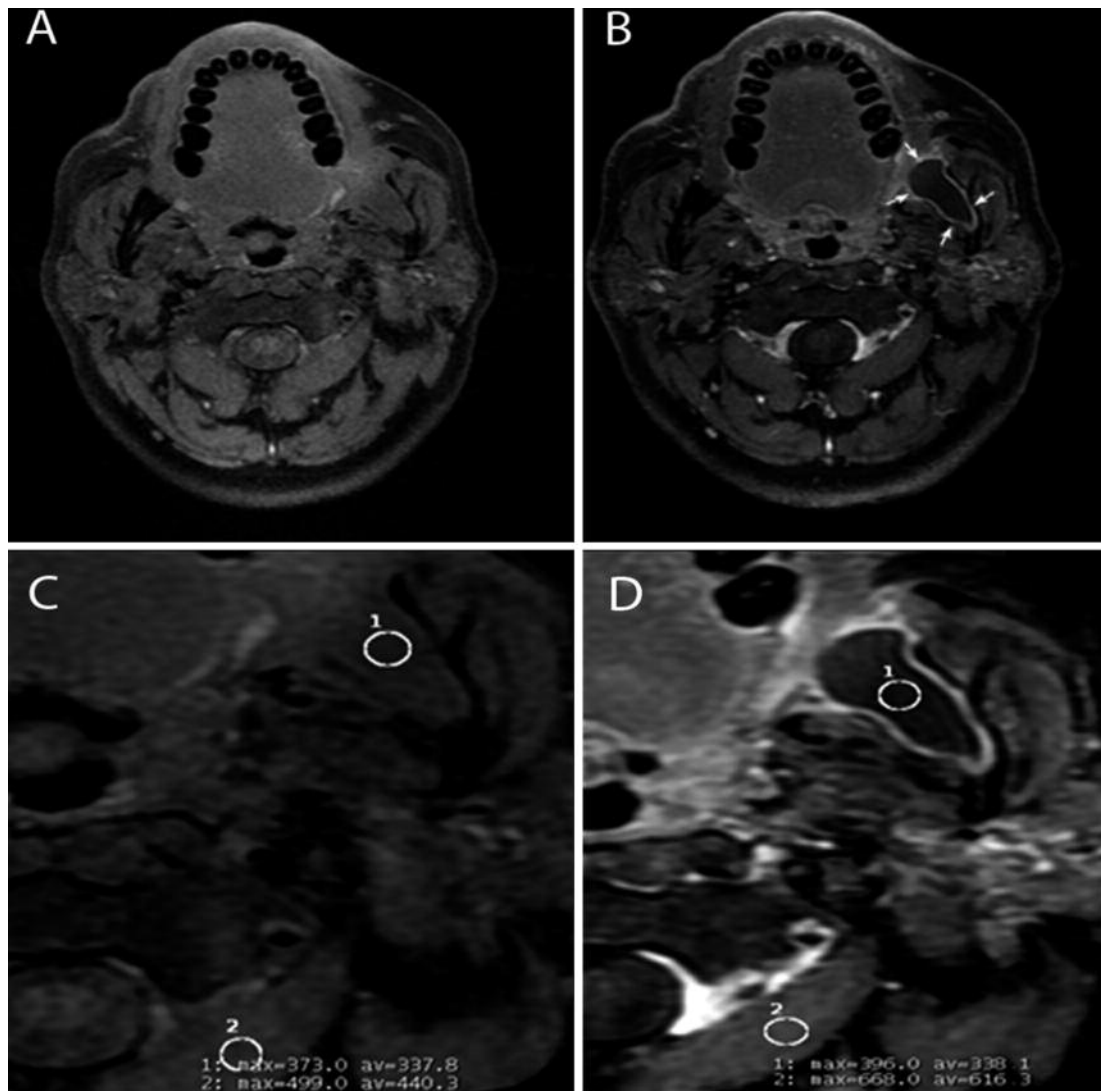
T1-weighted axial images fat-saturated fast spin echo (Ax T1 Fs FSE). A, Pre-contrast administration (Ax T1 Fs FSE pre-CE). B, Post-contrast administration (Ax T1 Fs FSE post-CE). The post-CE acquisition shows that the contrast is confined to the margin of the lesion, characteristic image of the benign tumour with the presence of a capsule. Two ROIs corresponding to the lesion (1) and to the muscular tissue (2) were determined in the pre (C) and post-contrast administration (D) sequences. A significant different gradient between the two sequences was detected only in the muscular tissue. Consequently no mass enhancement was observed.
